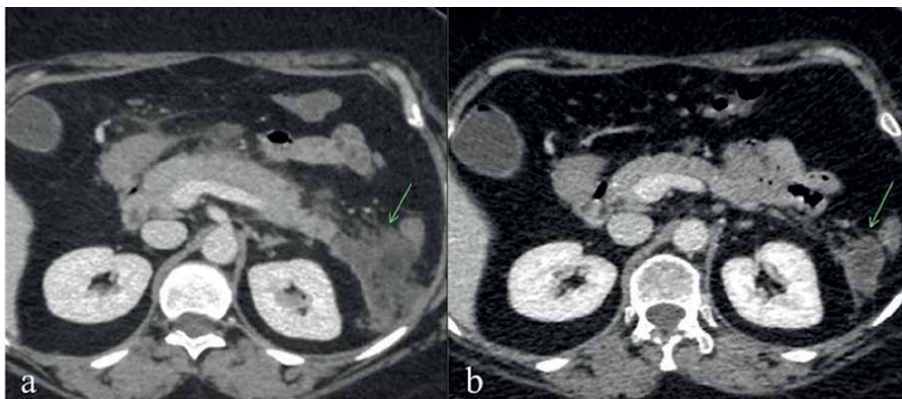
M, 49 yo. CT images show acute peripancreatic fluid collections (a) within four weeks from the onset of interstitial edematous pancreatitis and the development of a pseudocyst four weeks later (b).
